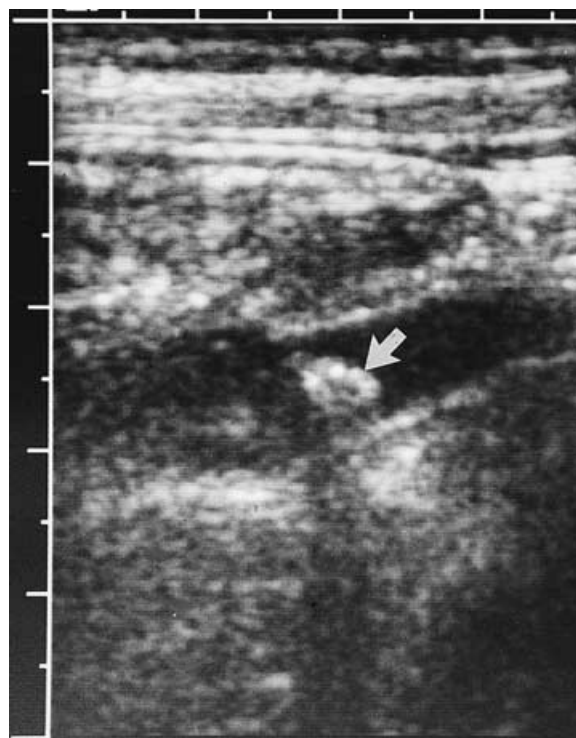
Acute appendicitis. On ultrasonography, a radiographically nonopaque appendicolith (*arrow*) is evident within a thick-walled, distended appendix (longitudinal view).
